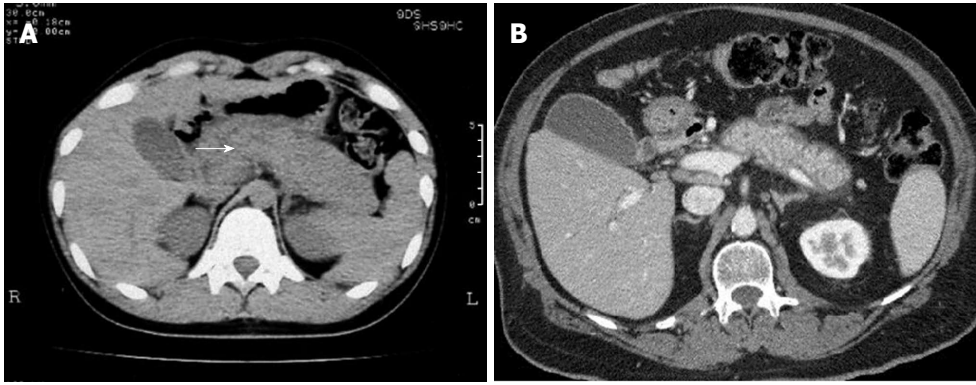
Computed tomography. A: Computed tomography (CT) findings in autoimmune pancreatitis: Showing diffuse enlargement and a “sausage like” appearance of the pancreas (arrow); B: Axial contrast enhanced CT image demonstrating a characteristic low signal rim or halo surrounding the body and tail of the pancreas in another patient with autoimmune pancreatitis.
